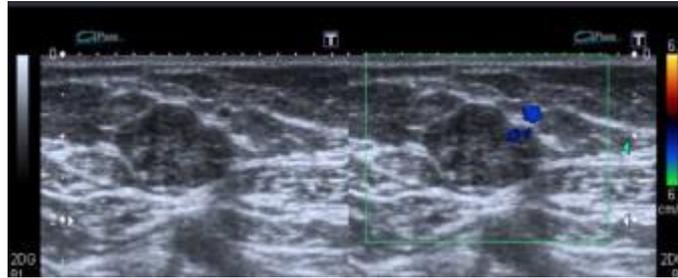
B-mode ultrasound shows a well-defined macrolobulated outlined hypoechoic solid mass (BI-RADS 3).
